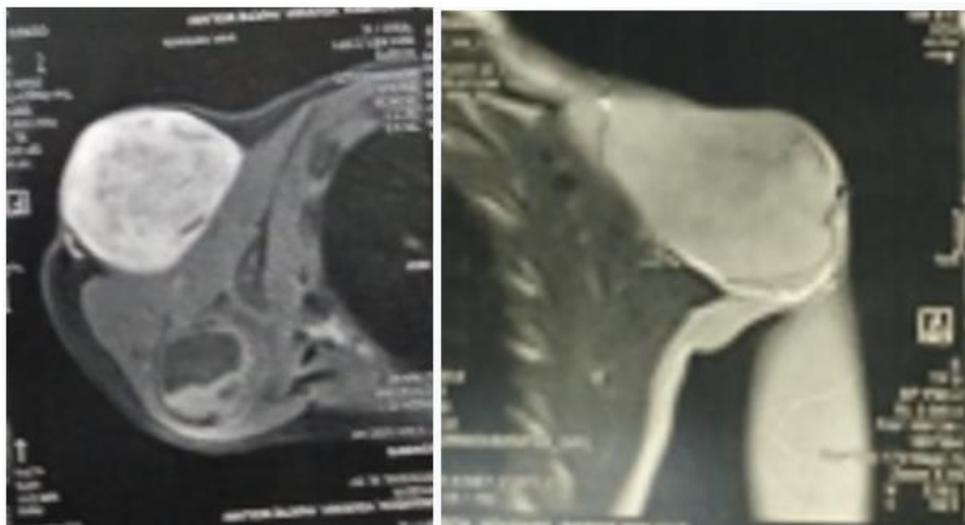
Haemangioma of the left shoulder on MRI
